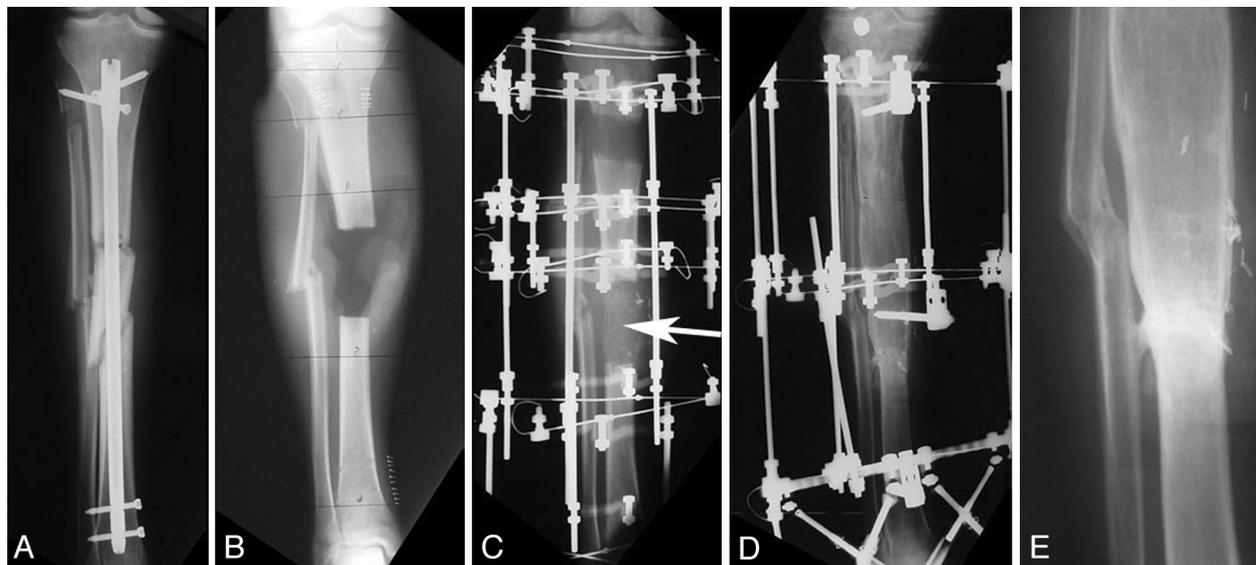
Associated infection of bone/active draining infection. (A) Anteroposterior radiograph of a severe open tibia fracture referred in 3 months following intramedullary nail fixation at an outside facility. The patient presented with abundant gross purulence draining from a large open wound with exposed bone and hardware. (B) Anteroposterior radiograph following bony resection and removal of the intramedullary nail. (C) Anteroposterior radiograph during bone transport using the Ilizarov method. Note the early regenerate at the proximal corticotomy site. Also note that the docking site cavity had been grafted with copious cancellous autograft bone (arrow) at the time of final soft tissue coverage using a free flap. (D) Anteroposterior radiograph in the Ilizarov external fixator following successful bone transport. Note the maturation of the regenerate and solid healing at the docking site without the need for further operative bone grafting procedures. (E) Final anteroposterior radiograph following Ilizarov removal shows solid healing at the docking site.
